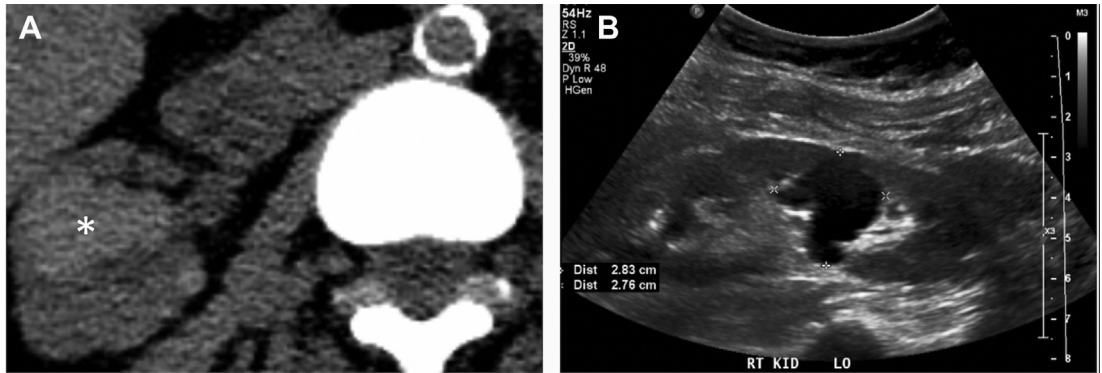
A 66-year-old man with a 3.2-cm homogeneous right renal mass on noncontrast CT scan (*asterisk*), with a mean attenuation of 42 HU (A). A renal ultrasound examination was performed and demonstrated a hypoechoic cystic renal mass with small amounts of internal debris (B), most likely representing a hemorrhagic renal cyst and compatible with a Bosniak type II renal cystic mass. Given the size of this renal cystic mass on noncontrast CT scan, renal MR imaging could have been ordered instead of a renal ultrasound examination to look for occult enhancing elements (see footnote in [Table 1](#)), although that was not done in this case.
